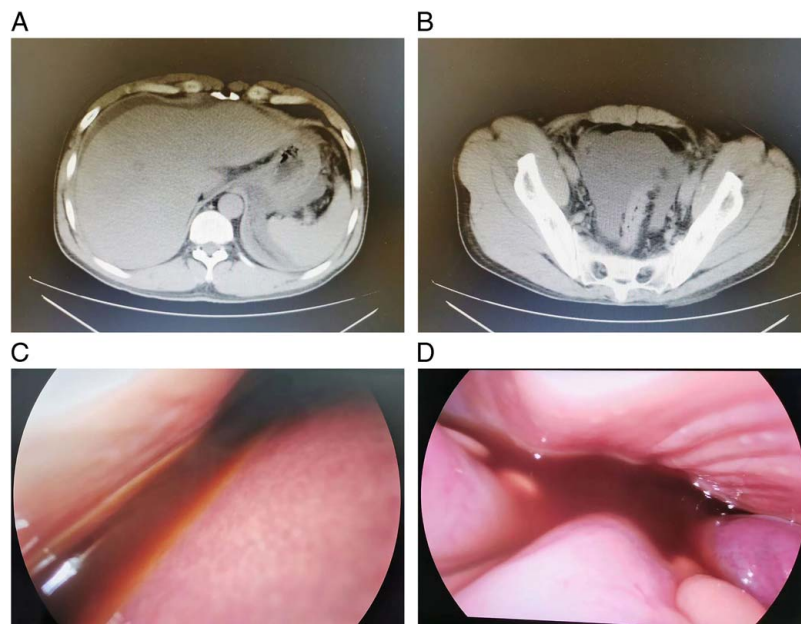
A 39-year-old male with acute pancreatitis. The upper abdominal CT scan revealed the presence of perihepatic effusion (A). The pelvic CT scan demonstrated the existence of pelvic effusion (B). Laparoscopic exploration unveiled a substantial volume of coffee-like and cloudy pancreatic ascites in both perihepatic and pelvic regions (C, D).
